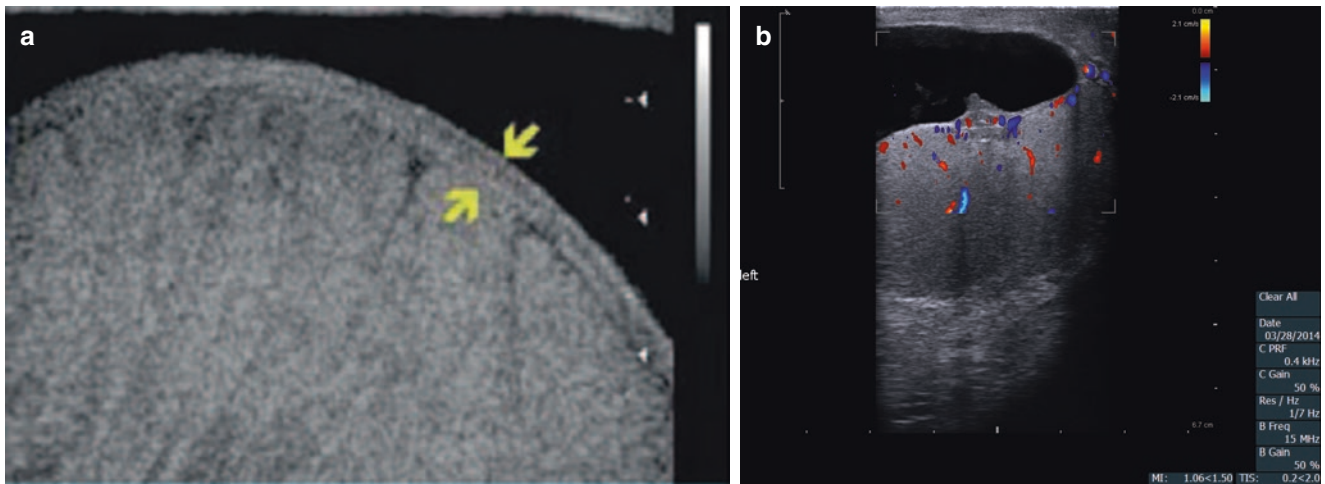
(a) The tunica albuginea is a thin ring of fibrous tissue surrounding the testis, and appears hyperechoic on gray scale ultrasound. It is indicated by an arrow (From Gilbert [3]; with permission). (b) In
